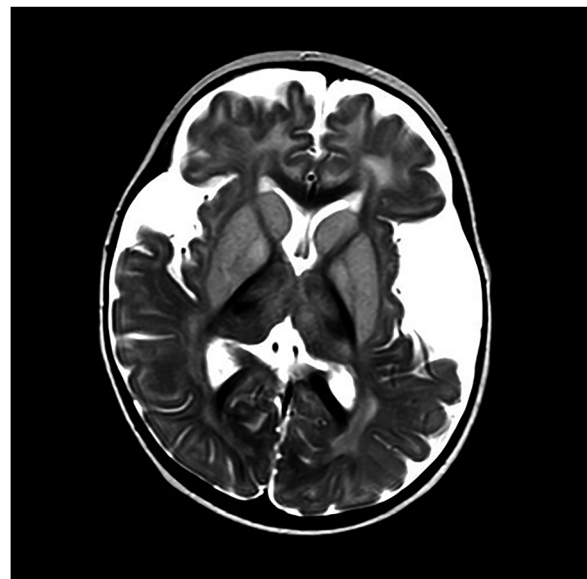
Cranial MRI of the patient: T2-weighted image revealed opercular frontotemporal atrophy, bilateral subcortical and periventricular white matter, bilateral basal ganglia involvement, and thalamic hyperintensities.
